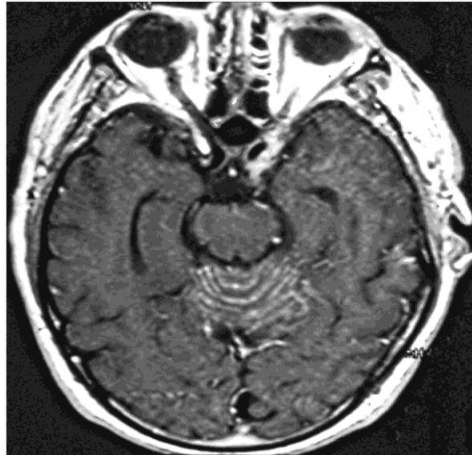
Early MRI showing inflammation of the cerebellum in Non-Hodgkin lymphoma (PNS)
